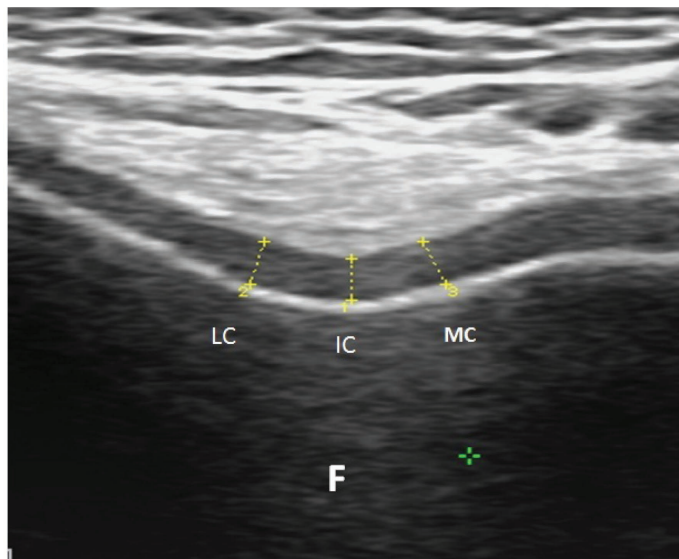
Ultrasonographic image (suprapatellar axial view) demonstrating the femoral cartilage measurements (LC: lateral condyle, IC: intercondylar area, MC: medial condyle, F: femur).
